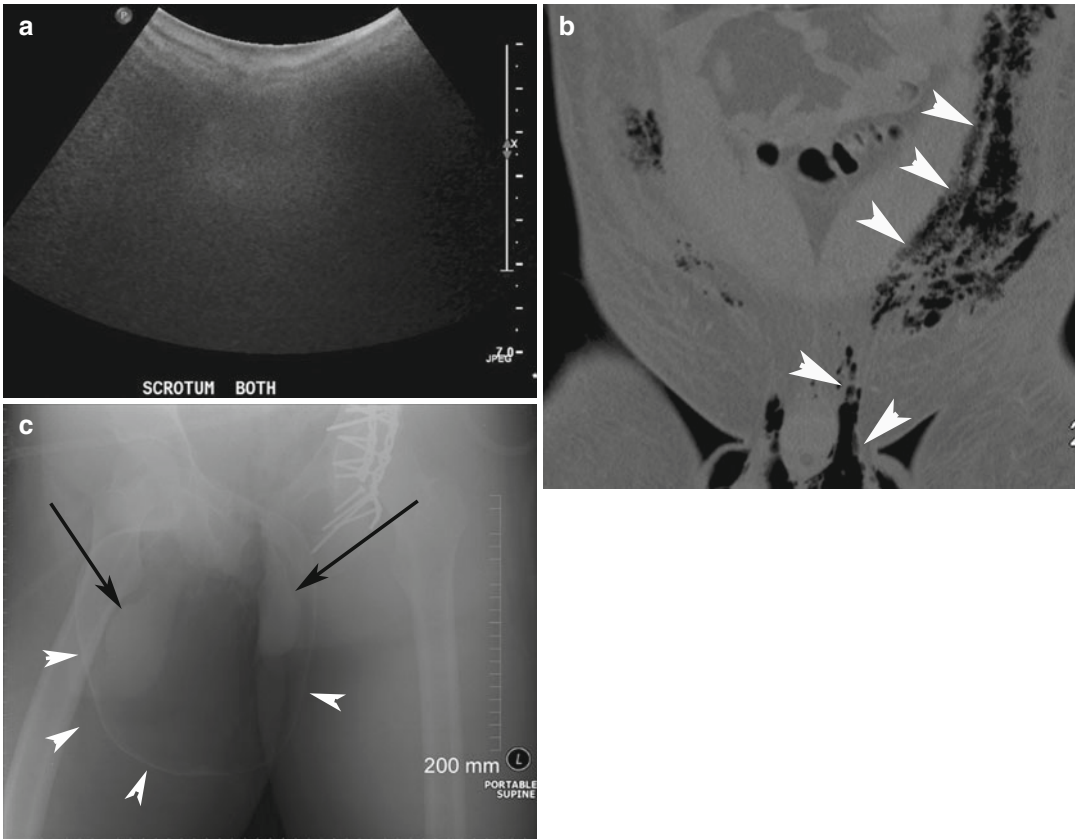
Twenty-seven-year-old man with polytrauma 2 days previously. An acutely enlarged scrotum was noted when the patient was in the operating room for repair of a complex hip fracture. Patient had been placed in Trendelenburg position for several hours. (a) Ultrasound image fails to identify any normal structure in the scrotum
